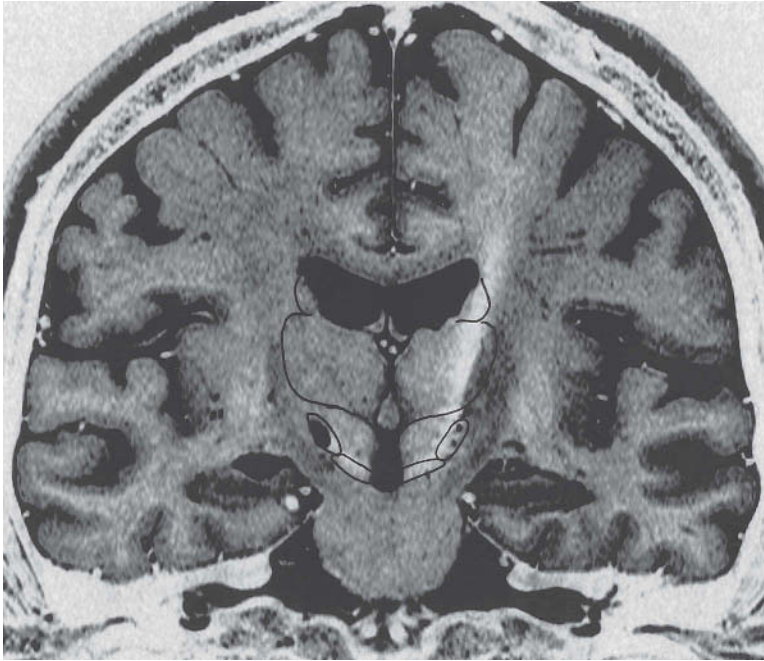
Postoperative inverted coronal T2 weighted MRI scan showing lesion location (this patient also had an implanted left subthalamic DBS electrode).
